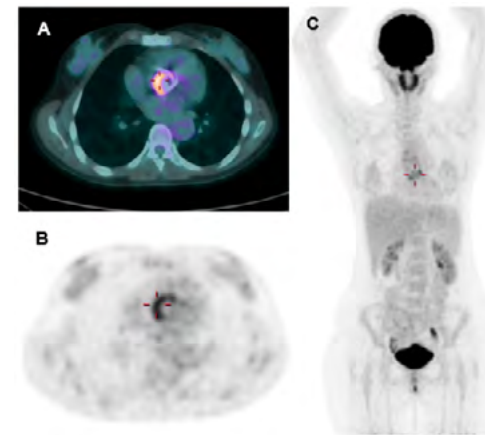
^{18}F -FDG PET/CT performed in a 33-year-old female with biological prosthetic aortic valve. The PET/CT fusion transaxial image (A) shows a linear increased uptake in the right region of the valve. This pathological uptake is suspicious for IE. PET image (B) and maximum intensity projection (C) of the same patient.
